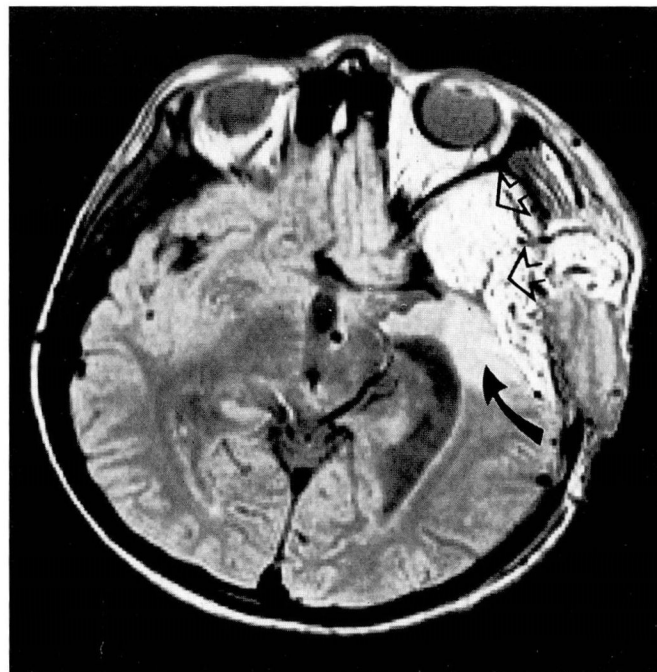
Transverse MR image of the head (1.5 Tesla, TR=2010, TE=32 ms) after subdural omental transposition. Note obliteration of dead space (open arrows). Areas of white matter with increased signal (solid arrow) are thought to represent zones of venous infarction due to the patient's empyema.
